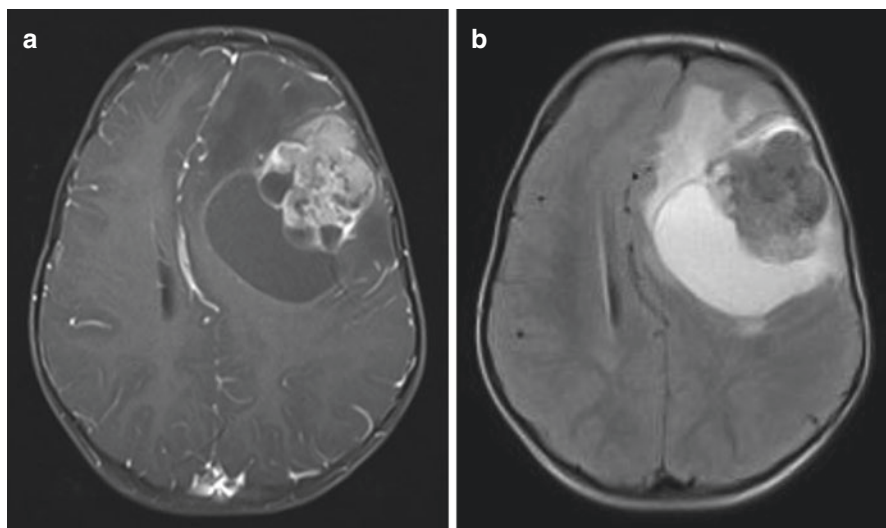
MRI of supratentorial AT/RT in a 19-month-old boy. (a) Axial T1 with contrast. (b) Axial T2 FLAIR sequence
